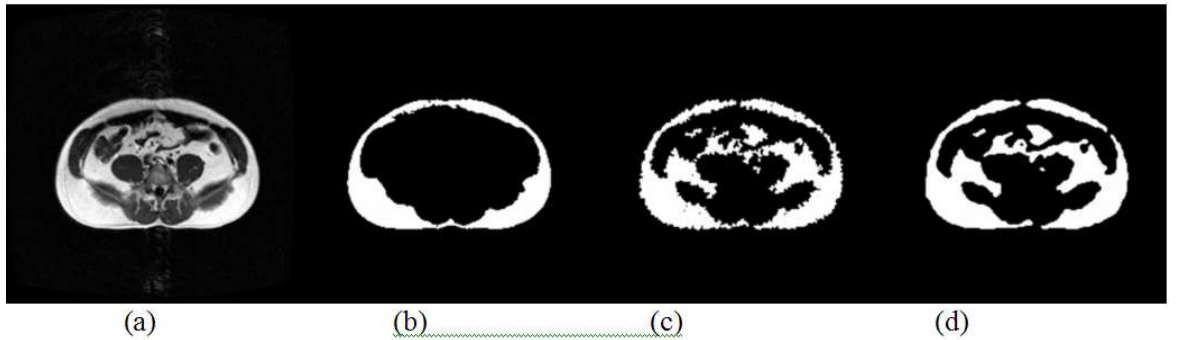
Quantification of adipose tissue from whole body MRI scans. (a) Input data MRI T1 image, (b) Training (simple FC), (c) Segmented Image VD classification, (d) Smoothed segmented image visceral and subcutaneous tissue.
